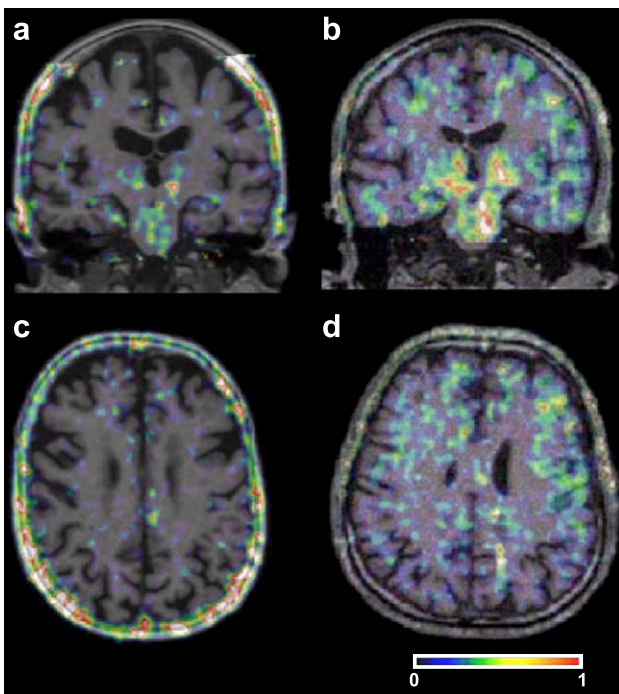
Coronal and transverse $[^{11}\text{C}](\text{R})\text{-PK11195}$ PET binding potential maps co-registered with T1-weighted MR images in control (a, c) and ALS patients (b, d), demonstrating visibly increased signal in the region of the thalamus and pons (b); and frontal lobe (d). The colour scale is calibrated for $[^{11}\text{C}](\text{R})\text{-PK11195}$ binding.
